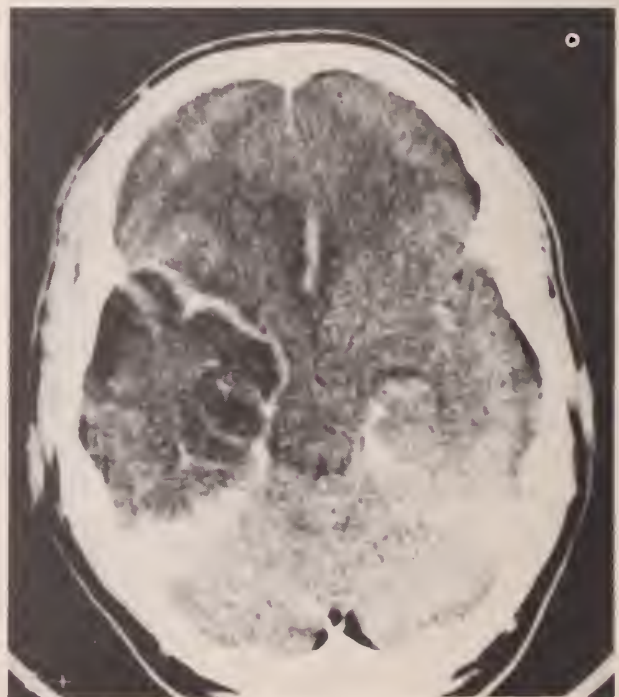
CT head scan following IV contrast. Abnormal low density is again seen throughout the right temporal lobe. Abnormal contrast enhancement is seen about the peripheral margins of this lesion. Less intense streaky, curvilinear areas of abnormal enhancement can be seen within the lesion.
